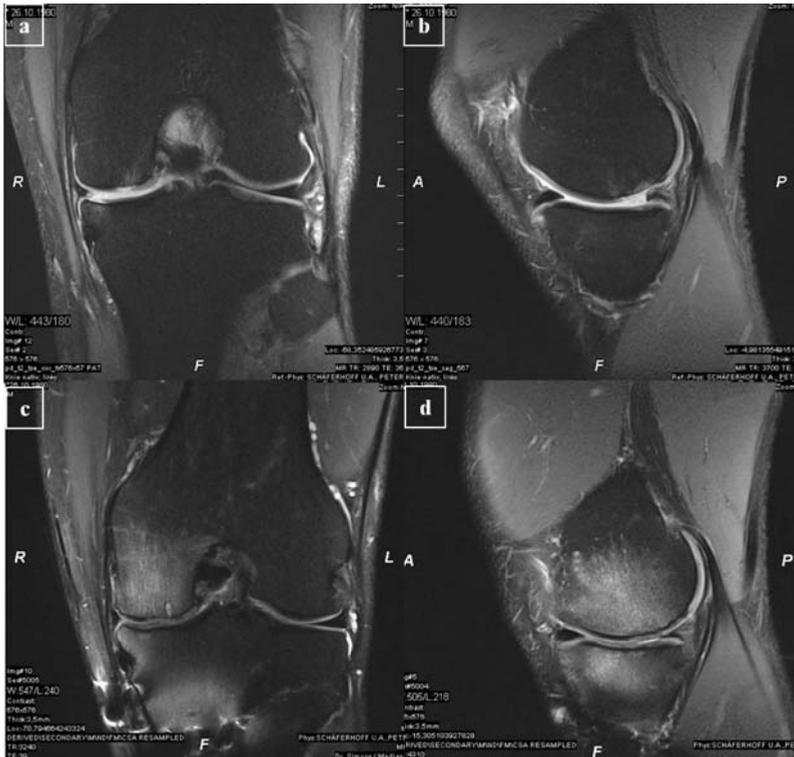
MRI of the cartilage lesions preoperative (a+b) and 20 month postoperatively (c+d).
